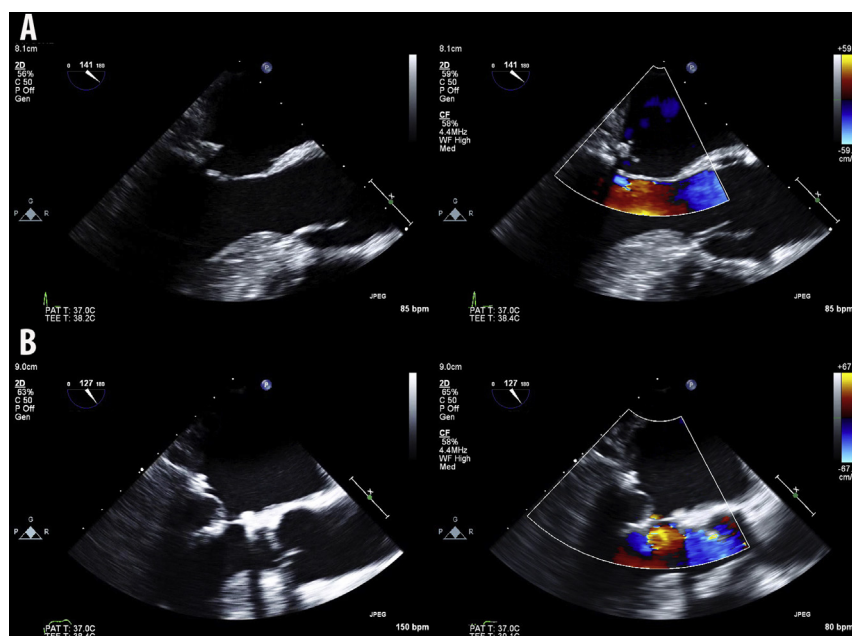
Typical echocardiographic appearances after MV repair. (A) Appearances after quadrangular resection for P2 prolapse (late systole, midesophageal long axis view). With 2D imaging (*left frame*), a short bulky posterior leaflet is seen, and there is an apparent systolic coaptation defect. The bulky appearance is due to the annuloplasty band, and the apparent coaptation defect is due to echocardiographic dropout from the annuloplasty band, obscuring the coaptation point. Thus, coaptation height cannot be assessed. In this case, a partial annuloplasty band has been used. No MR is evident with color Doppler imaging (*right*), despite the apparent coaptation defect (due to echocardiographic dropout). (B) Appearances after placement of neochordae for P2 flail (late systole, midesophageal long-axis view). With 2D imaging (*left*), the posterior leaflet is well seen, and the coaptation height is obviously satisfactory. The annuloplasty ring is well seen posteriorly and anteriorly. With color Doppler imaging (*right*), a trivial amount of MR is seen.
